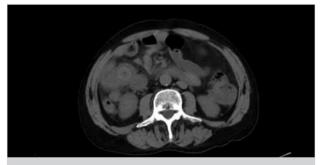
In the case undergoing Roux-Y reconstruction after gastrectomy, herniation of ileal loops from the space in the dorsal of roux limb meso in non-contrast abdominal CT
